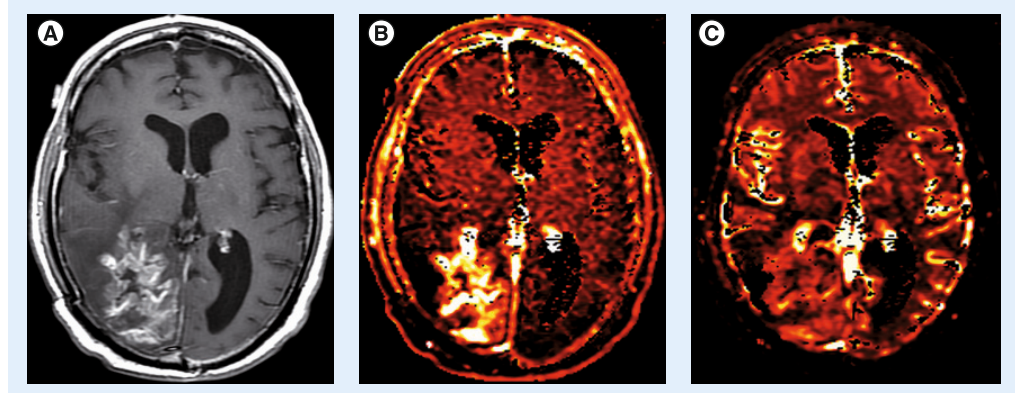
Dynamic contrast-enhanced perfusion in radiation injury. (A) Axial contrast T1-weighted image obtained 1 year after treatment for a glioblastoma shows an increasing ill-defined enhancing mass lesion in the temporal lobe, and (B) a smaller lesion along the posterior medial margin of the surgical cavity. (C) The volume transfer coefficient map demonstrates moderately increased leakiness while the plasma volume map reveals no abnormal hyperperfusion, suggesting that the enhancement is related to blood–brain barrier disruption and radiation injury rather than tumor.
